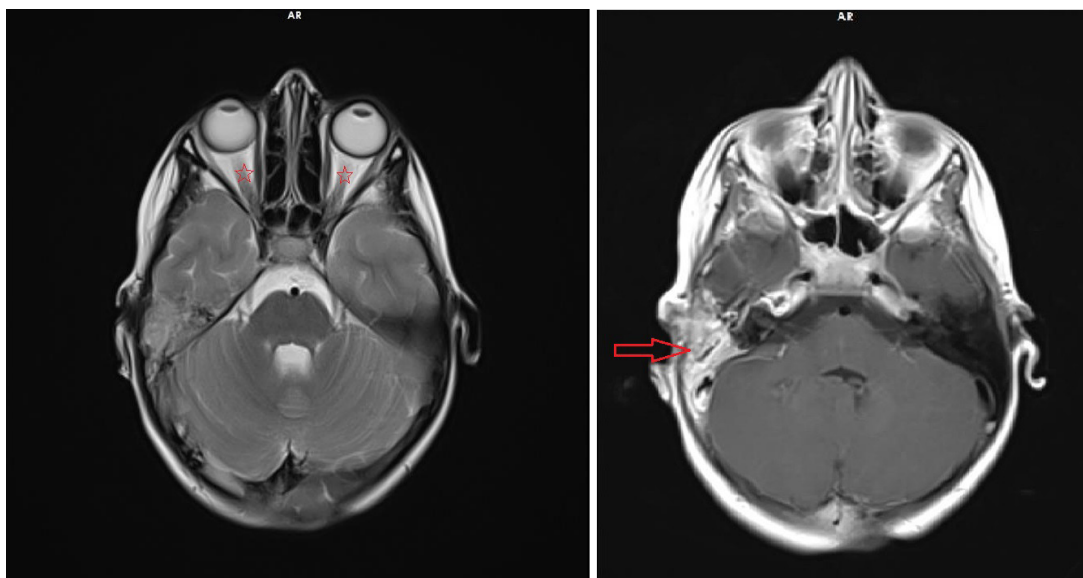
The brain MRI showed bilateral papilledema (marked by stars), thickening of the sphenoid mucosa, and fluid collection in the right mastoid air cell (highlighted by a red arrow), confirming a diagnosis of right-sided otomastoiditis.
